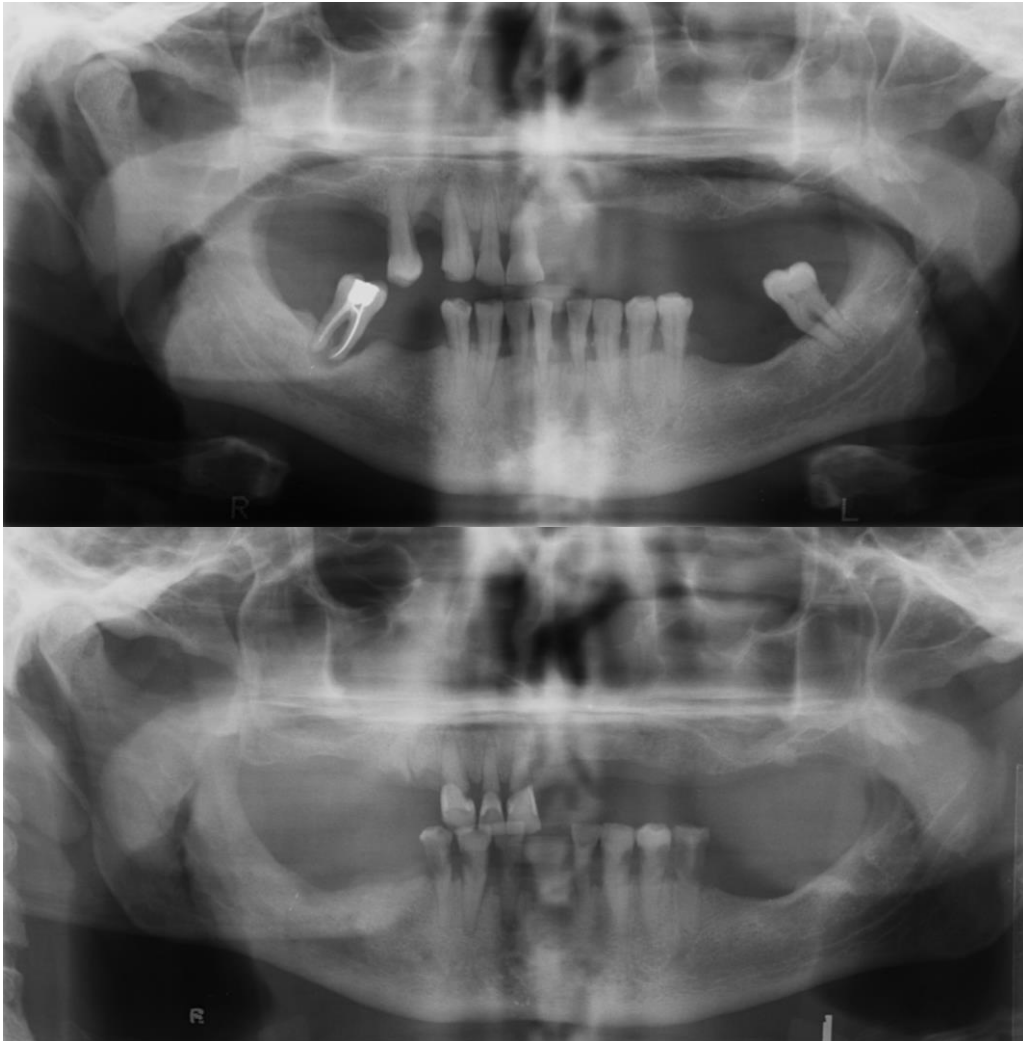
OPT radiograph before and after radiotherapy showing dental caries as an indirect consequence of radiotherapy which rendered the patient edentate.
